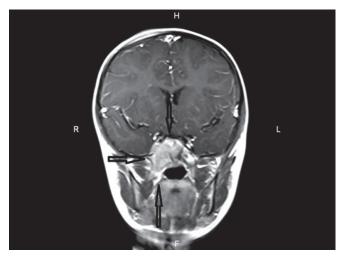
Coronal T1 postcontrast MRI showing lesion extended to the parapharyngeal space
